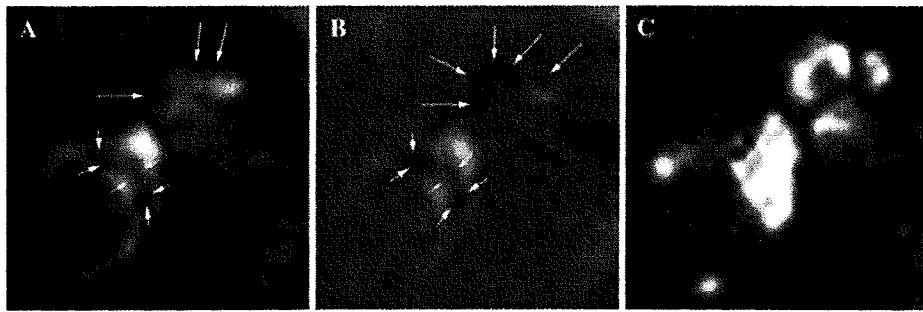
MRI of case 3. a 3D FLAIR shows an enlarged endolymphatic space in the cochlea (*arrows*) as a low signal area. However, the boundary between the endolymphatic space and surrounding bone is unclear. Moderate enlargement of the endolymphatic space in the vestibule (*short arrows*) was observed. b A 3D-real IR sequence visualizes remarkably enlarged endolymphatic space in the cochlea (*arrows*)
